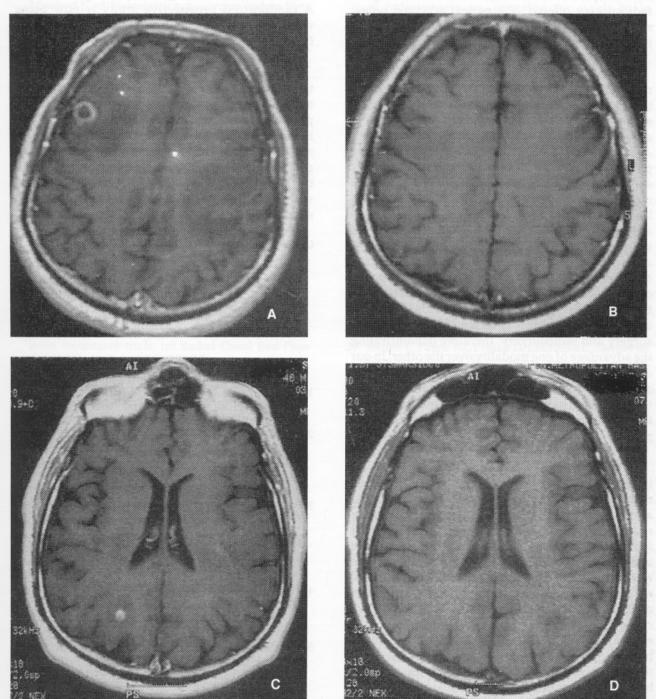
MRI images of a patient who presented with non-small cell lung cancer and underwent radiosurgery twice for the treatment of the metastatic disease to the brain.
